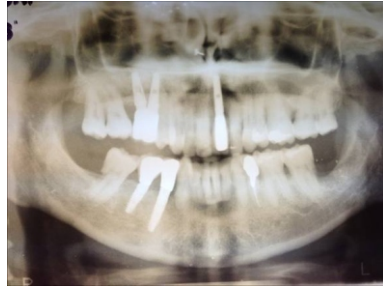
The orthopantomography shows the sinus pneumatization with loss of maxillary sinus floor cortical bone due to 2.5 dental agenesis
